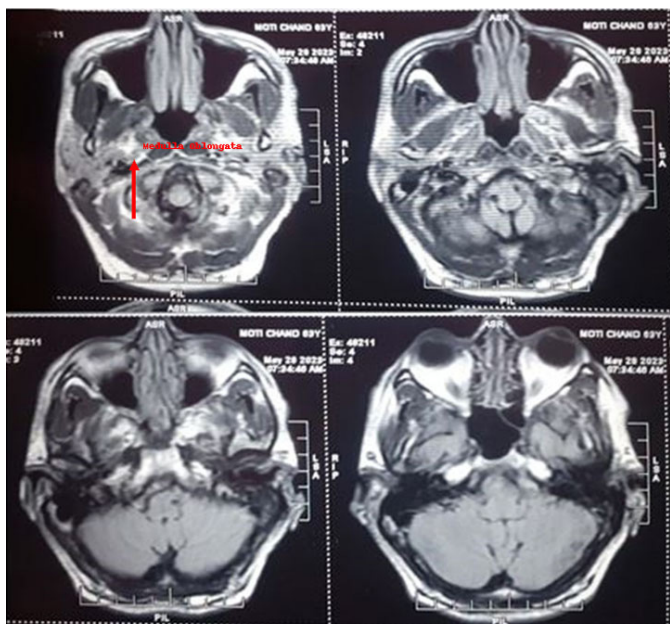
Axial T1-weighted MRI brain images showing chronic ischemic changes in the medulla oblongata region (indicated by red arrow).
